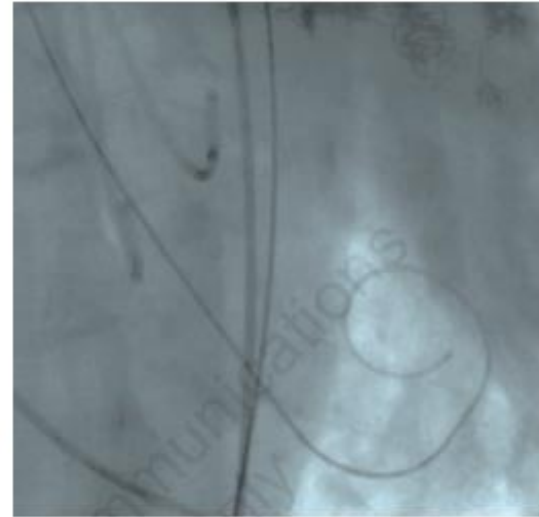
Intraoperative chest x-ray image demonstrating the presence of a preshaped stiff wire in the left ventricle and two pigtail catheters in the left coronary sinus and the non-coronary sinus.
